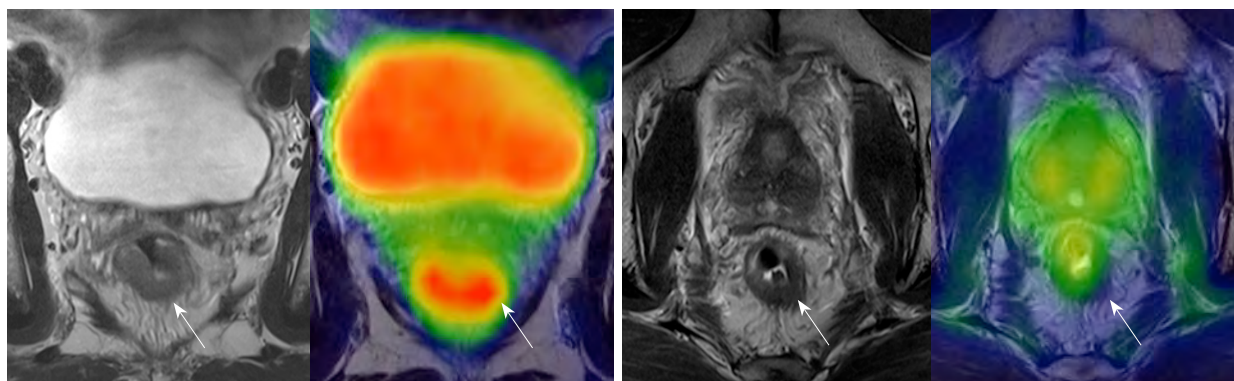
Good response to preoperative chemoradiotherapy (CRT). (A) Preoperative positron emission tomography/magnetic resonance imaging (PET/MRI). (B) Post-CRT PET/MRI. Arrows indicate the rectal tumour.
